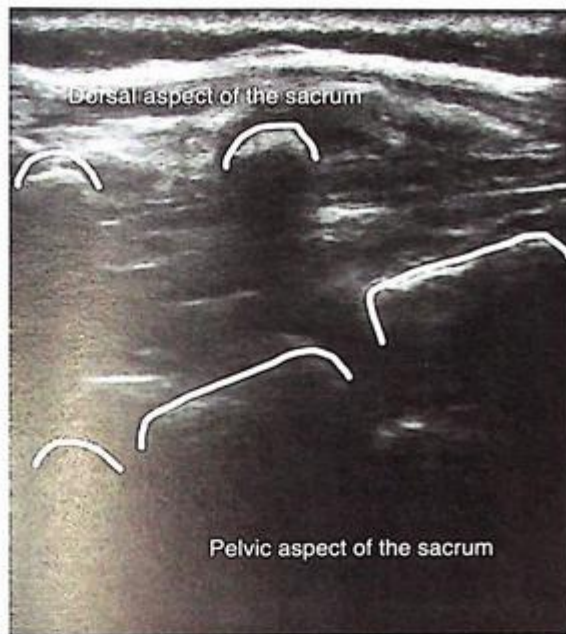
Ultrasound still of anatomy of caudal block in pediatrics.
